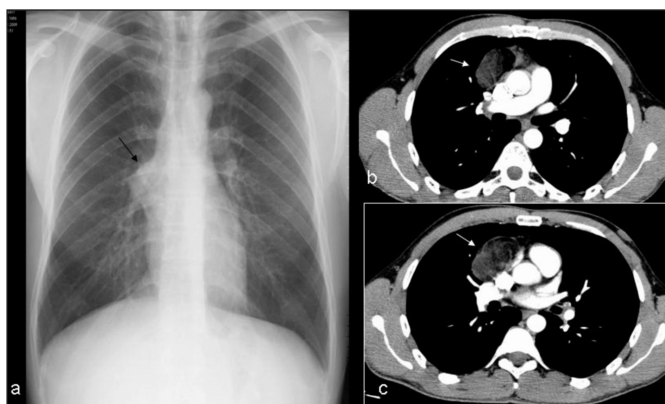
Posteroanterior chest radiograph (a) of a 37-year-old male patient reveals a smooth edged opacity, giving silhouette right hilum border. Axial CT (b,c) scan shows a non-homogeneous, well-marginated fat attenuation mass with soft-tissue components
